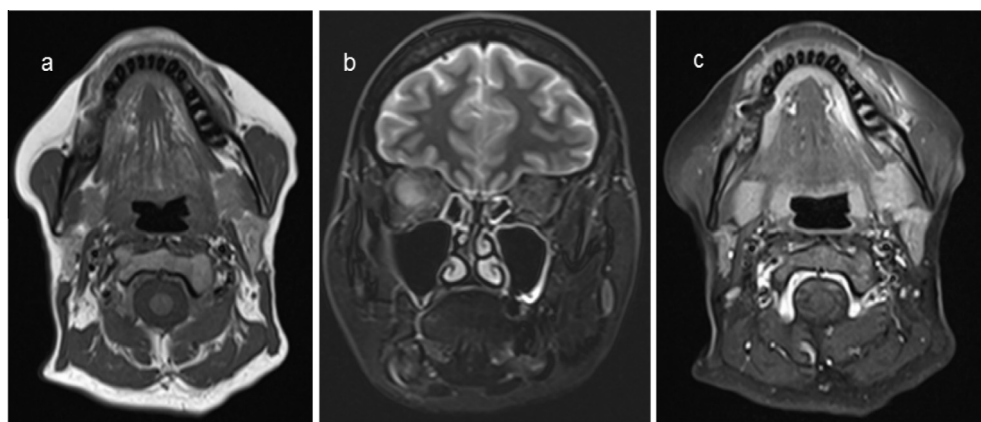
Follow-up MRI one month after initiation of bisphosphonate therapy with zoledronic acid. (a) Native axial T1-weighted MRI before a contrast agent was applied. Bone marrow signal remained decreased. (b) Coronal fat-saturated T2-weighted MRI indicates increased signal intensity in the right mandible. (c) Axial fat-saturated T1-weighted MRI with contrast agent administration. The slice shows decreased signal intensity in the right mandible due to the application of fat suppression and increased contrast medium uptake in the inflamed bone and the adjacent soft tissue.
